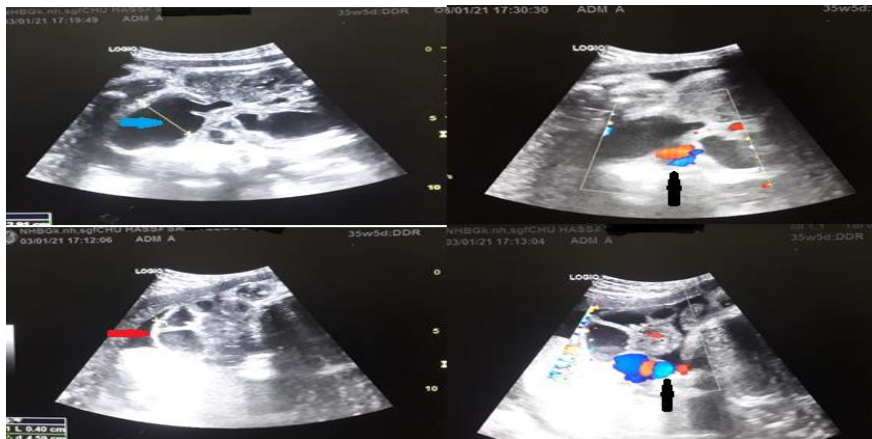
Prenatal ultrasound showing the appearance of gastroschisis: Blue arrow: bowel dilatation at 30mm. Red arrow: thickening of the digestive wall to 4mm. Black arrow: umbilical cord to the left of the gastroschisis image.
